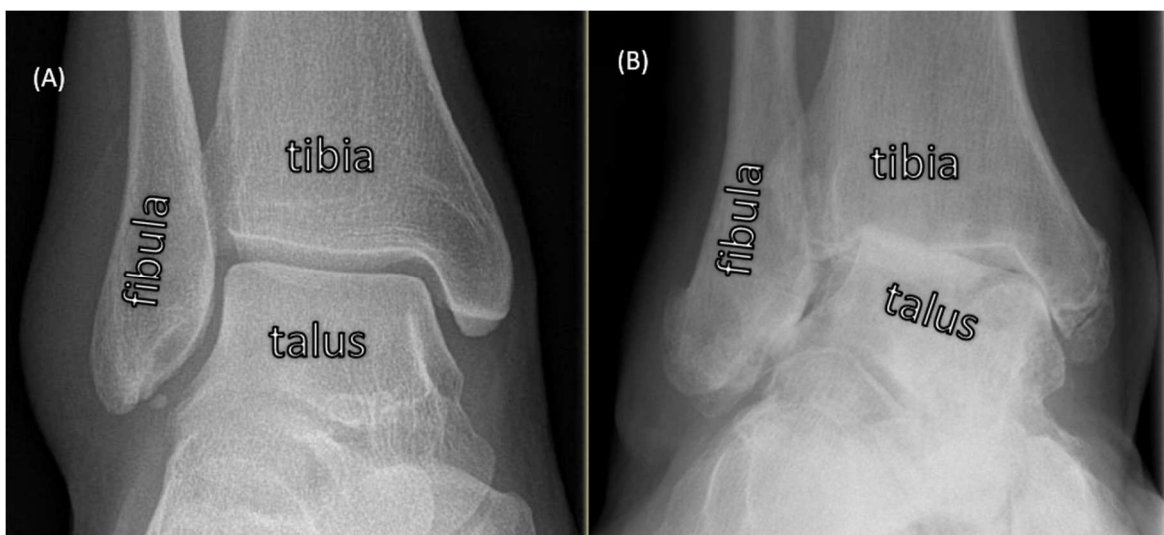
(A) X-ray image of a mortis formed by the tibia, fibula as they articulate with the talus in a healthy foot. (B) Talus everted from flat foot deformity (images from www.radiologyassistant.nl and from *The Bone School* [<http://52.62.202.235/>]).
